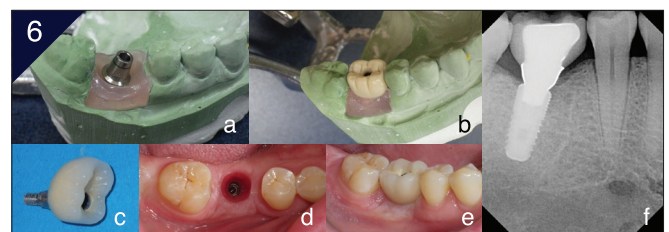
Screw Retained–Cemented Implant Crown (SR-CIC) protocol. Implant level impression is made 2-piece. DENTIS™ abutment is selected and placed on the cast. A metallo-ceramic crown is made with a hole at the occlusal surface, then cemented in the lab after removing the abutment from the cast. a) 2-piece abutment on the cast. b) Full contoured wax then a wax cut-back for an adequate porcelain thickness. c) Final crown cemented over the abutment. d) Occlusal view of the implant site. e) The implant crown over the DENTIS™ S-Clean implant. f) Final radiograph.
